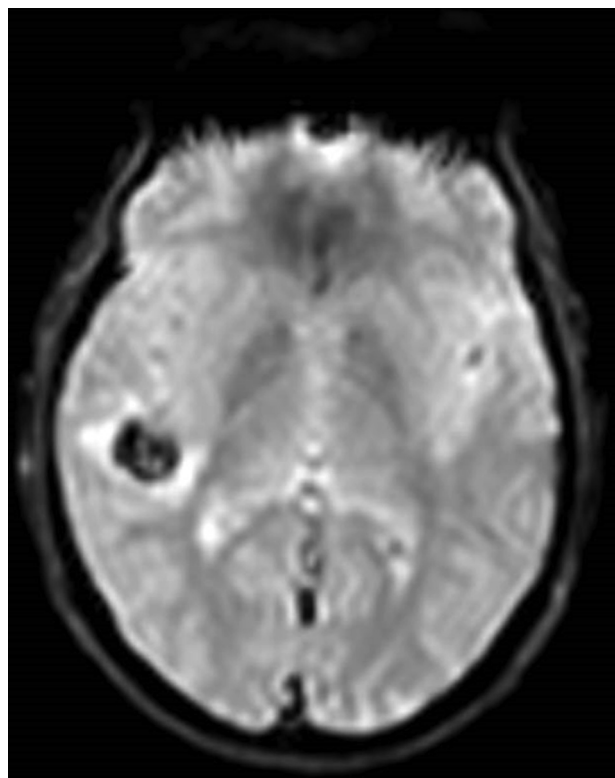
Case 3. Preoperative gradient echo magnetic resonance imaging sequence (axial view) showing a right temporal hemangioma.
